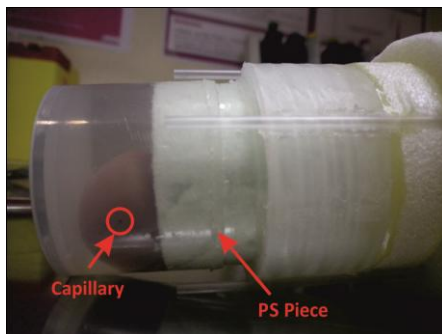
Kidney with the capillary inside the container before the CT measurement
